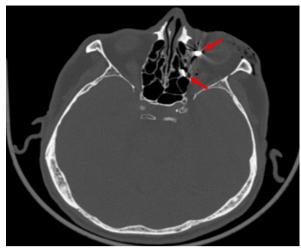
CT orbit axial view showing two radio-opaque foreign bodies at the ethmoid sinus and intraorbital region (arrow)
